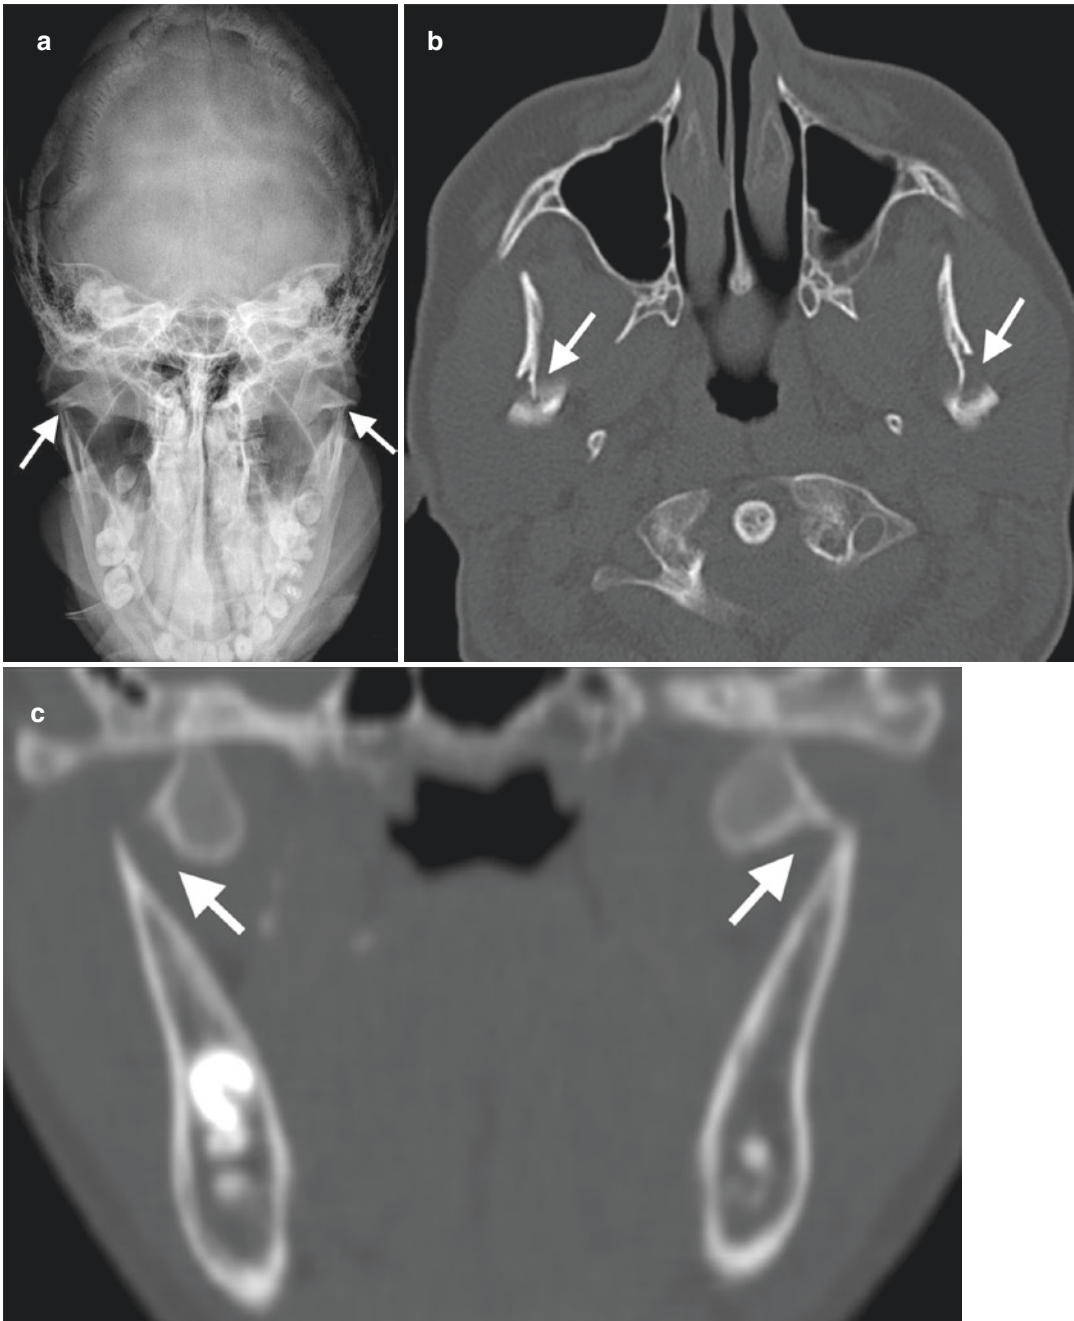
Bicondylar fracture. (a) Towne radiography reveals bilateral condylar fractures (arrows). Axial (b) and coronal (c) CT images show bilateral condylar fractures (arrows)
